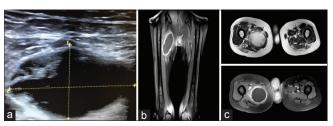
(a) Ultrasound showing 8 cm \times 4 cm cystic lesion. (b) Coronal T1-weighted magnetic resonance imaging. (c) Axial T2 magnetic resonance imaging. (d) Axial T1 with contrast. A well-circumscribed ovoid-shaped altered signal intensity lesion in the right adductor longus muscle
